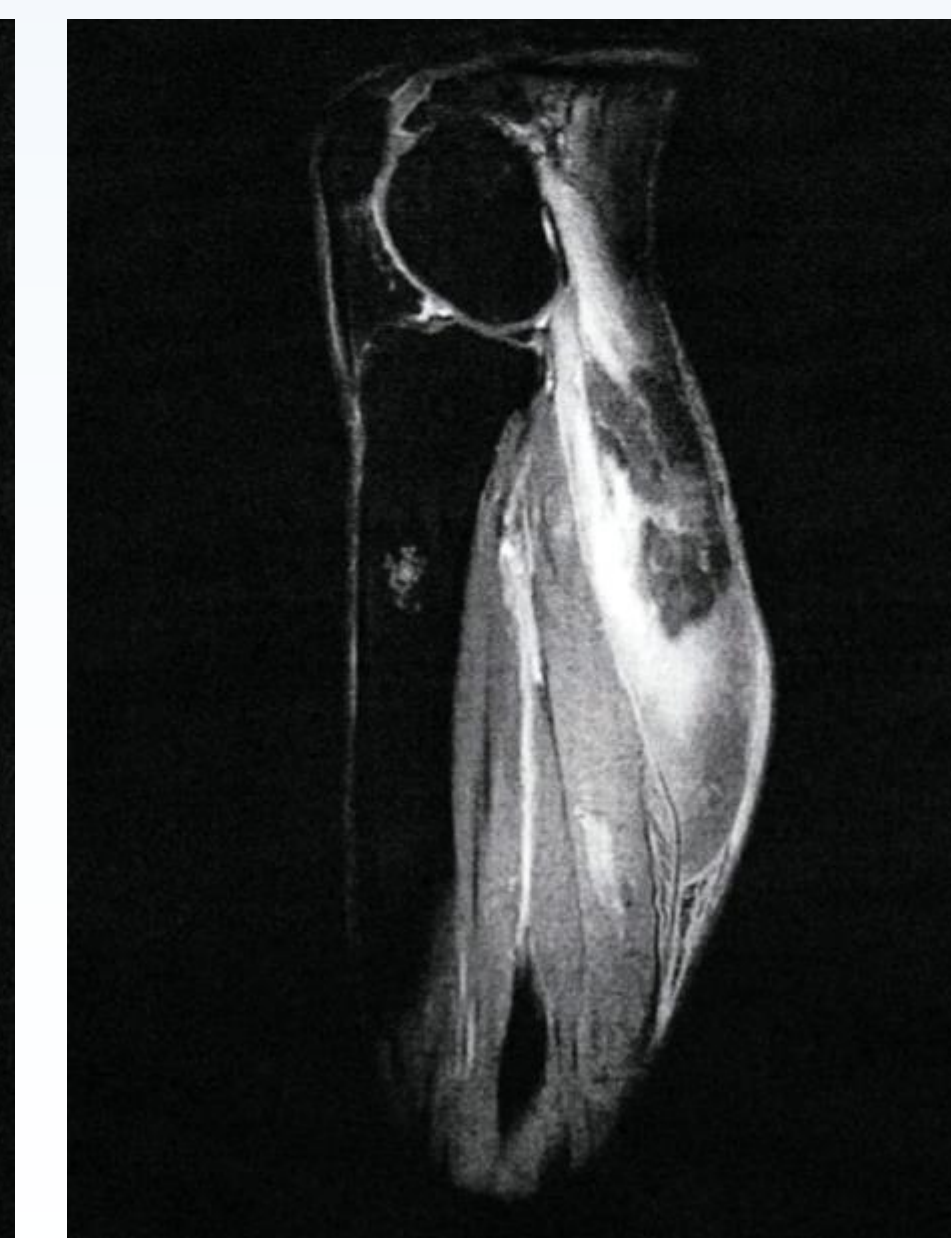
T1 weighted MRI
